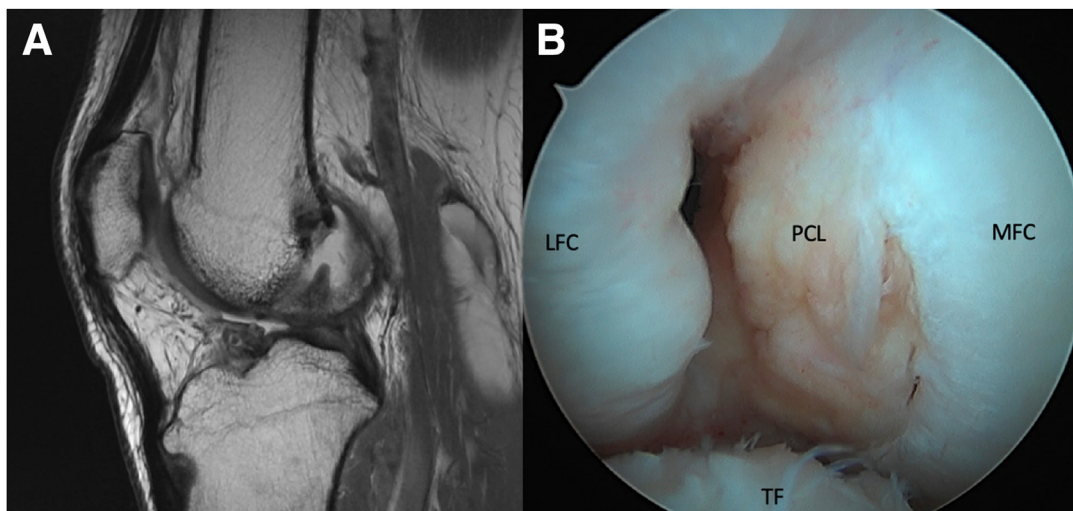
(A) Sagittal proton density magnetic resonance imaging of the right knee demonstrating lack of ACL graft in the femoral intercondylar notch, which was redemonstrated during arthroscopy through the anterolateral port, with no visible ACL fibers and significant overgrowth of the lateral aspect of the intercondylar notch. (ACL, anterior cruciate ligament reconstruction; LFC, lateral femoral condyle; MFC, medial femoral condyle; PCL, posterior cruciate ligament; TF, tibial footprint.)
